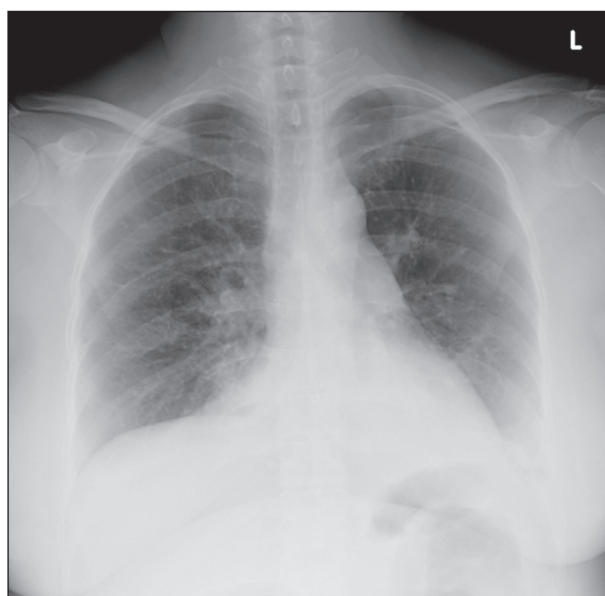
Follow up radiograph: resolved pulmonary edema 24 hours after therapy.
